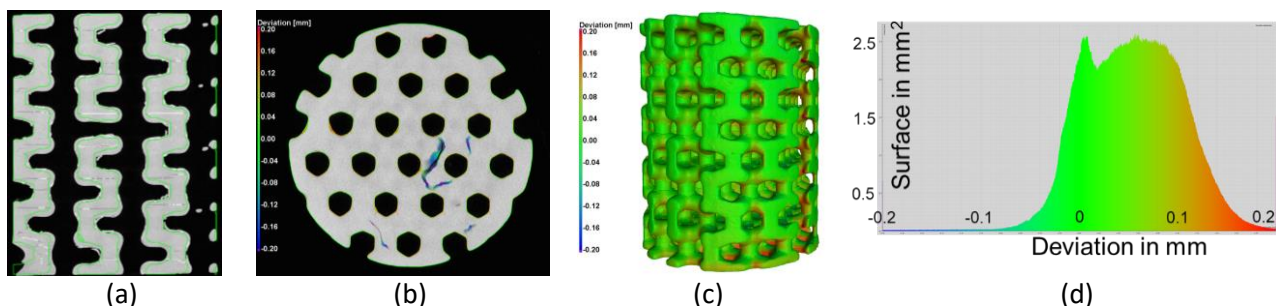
Industrial XCT measurement of the TCP cylindrical scaffold (a) lateral view of the XCT data; (b) top view of the CT data with some delamination defects visible; (c) complete nominal/actual comparison with the CAD file in colour code and (d) accumulated histogram of the nominal actual comparison.
